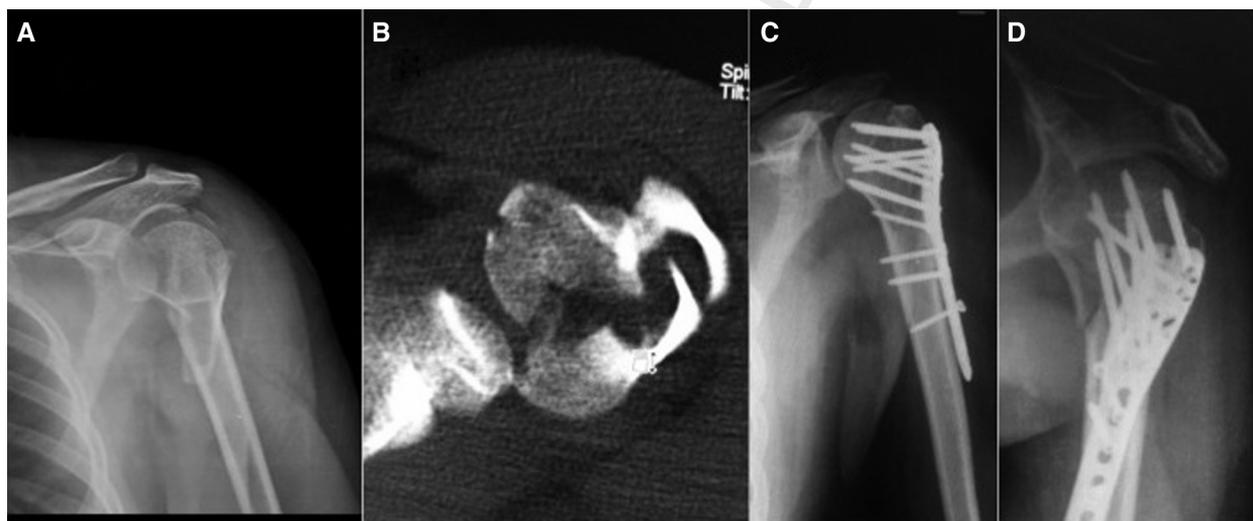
(A and B) Complex head-splitting fracture with a posteriorly dislocated head fragment. (C and D) At 6-week follow-up, radiographs show excellent reduction and fixation.
